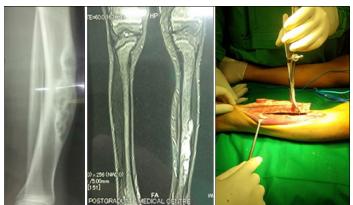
Osteolytic changes at the site of the lesion. Whorls with thinning of the tibial cortex and a narrow zone of transition are also evident. Figure-2.2: MRI scan of the right leg showing a hypo-intense lesion on T1-inverted image. Figure-2.3: Bone graft from iliac and contralateral fibula used for reconstruction.
